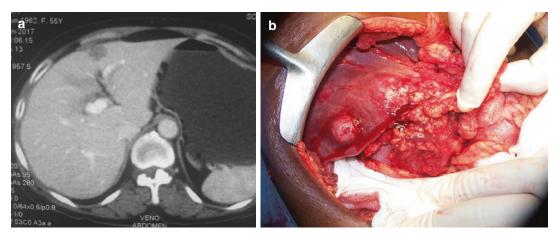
Liver metastasis (a) on CT (b) at operation
